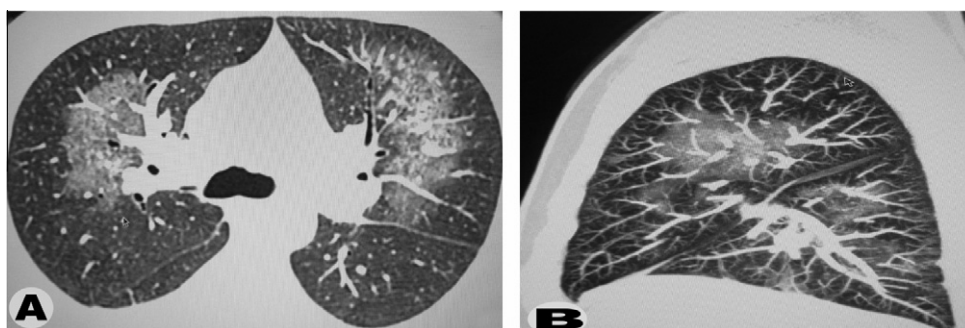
Female patient 16 years old suffered from dry cough and dyspnea, her PFTs shows a restrictive pattern, (A) axial CT scan shows reticular perihilar opacities in both lungs, (B) Sagittal MPR image shows the craniocaudal extent of the reticular opacities.
